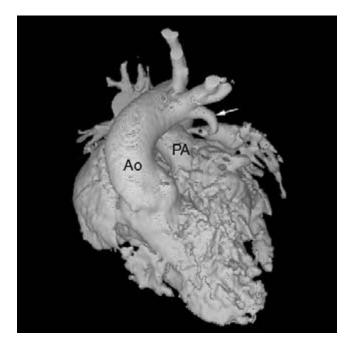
5 Three-dimensional CT angiogram shows discrete left pulmonary artery stenosis (asterisk) from contraction of a patent arterial duct (arrow) in a patient with tetralogy of Fallot. There is a right aortic arch and patent arterial duct arises from the left innominate artery. Ao, aorta; PA, main pulmonary artery. (Courtesy of Dr Yang Min Kim, The Sejong Heart Institute, Korea).
